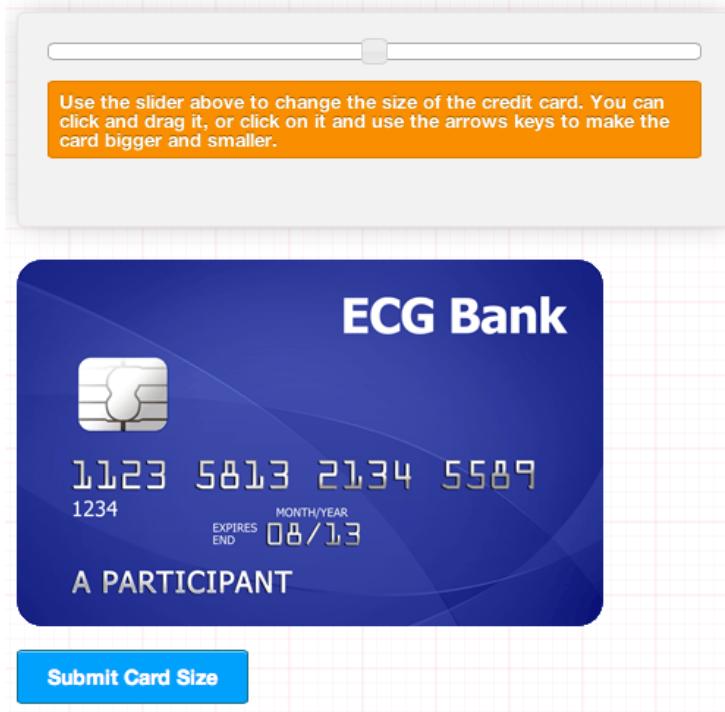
The RESPECT study calibration screen
